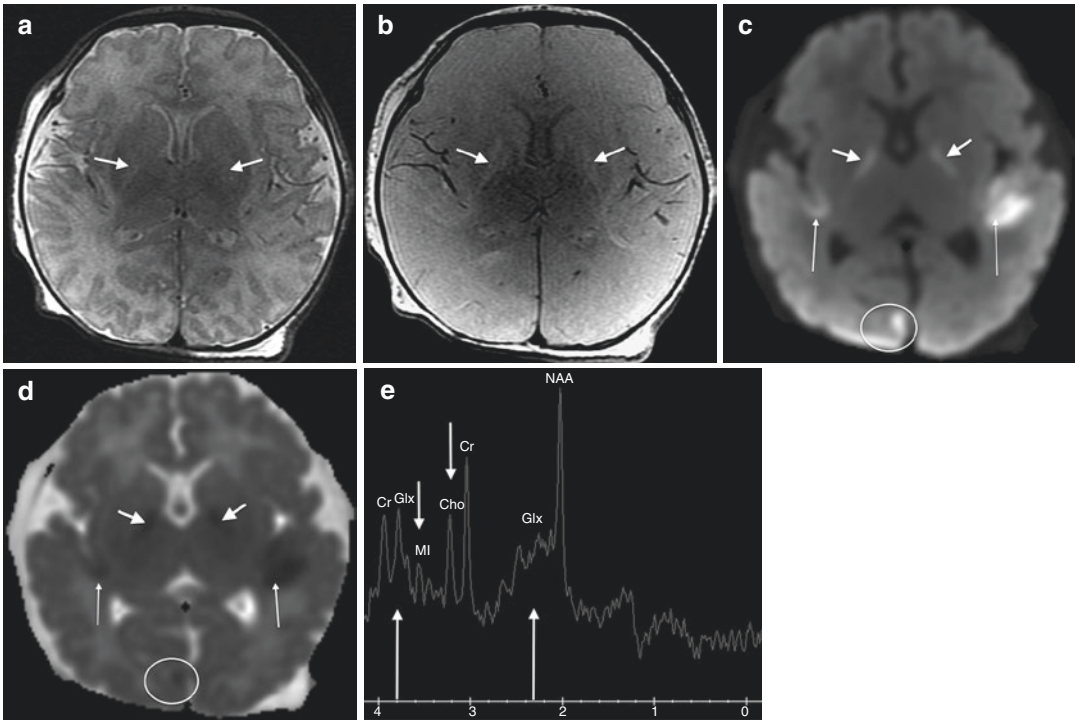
9-day-old male with a urea cycle disorder (ornithine transcarbamylase deficiency). Axial T2WI (TR/TE ms, 3500/90) (a), proton density (TR/TE ms, 3500/30) (b), DWI (TR/TE ms, 8000/81) (c), and ADC (TR/TE ms, 8000/81) (d) through the basal ganglia. Collectively, the globi pallidi and PLIC are abnormally hyperintense on proton density and T2WI (arrows, a and b) and demonstrate restricted diffusion (thick arrows, c and d) consistent with ongoing metabolic injury. Cortical/
